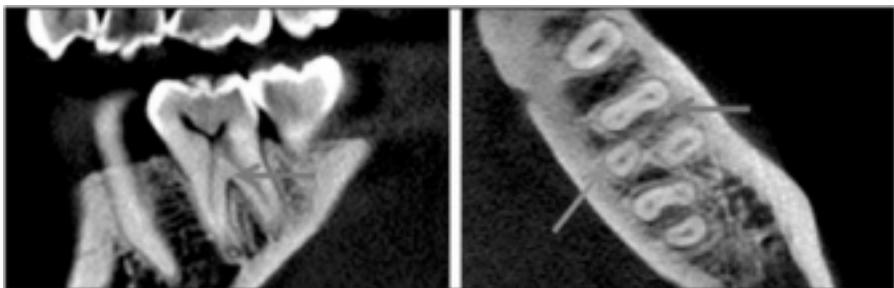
Cross-sectional cone-beam computed tomography image of a mandibular first molar with a clearly distinguishable distolingual root. The purple arrows denote the mandibular first molar and the orange arrows denote the distolingual root.
